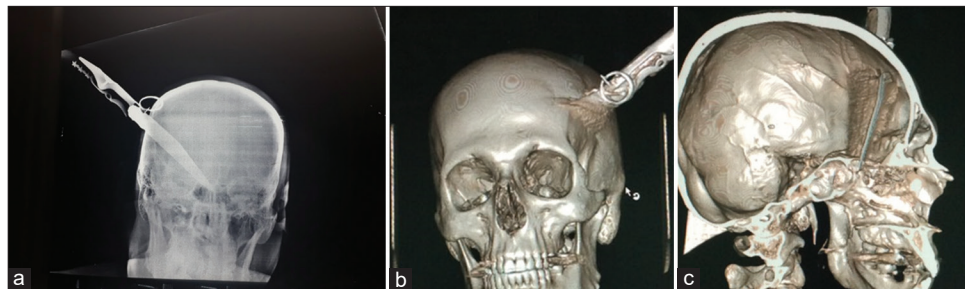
(a) Preoperative CT scan, sagittal section, bone window, (b) preoperative CT scan, sagittal section, 3D reconstructed, shows the knife stab penetrating the left Stephanion heading toward the cranial base, (c) preoperative CT scan, coronal section, 3D reconstructed shows the extension of the knife tip to the skull base (posterior ethmoidal sinus). CT: Computed tomography.
